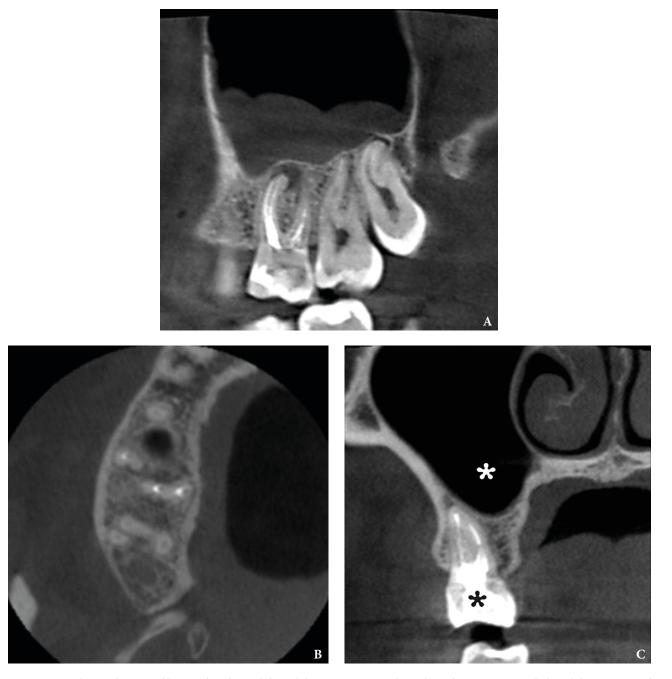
(A) Another sagittal CBCT scan of the patient from Figure 1 before endodontic retreatment. An axial (B) and coronal (C) CBCT scans 8-month after endodontic retreatment of the tooth 1.6 (*black asterisk*) shows no signs of chronic inflammation in the maxilla and maxillary sinus (*white asterisk*). Images of Figure 2 are courtesy of *Dr. Mariia A. Zimina, Zimina Dental Clinic*, Kyiv, Ukraine.
